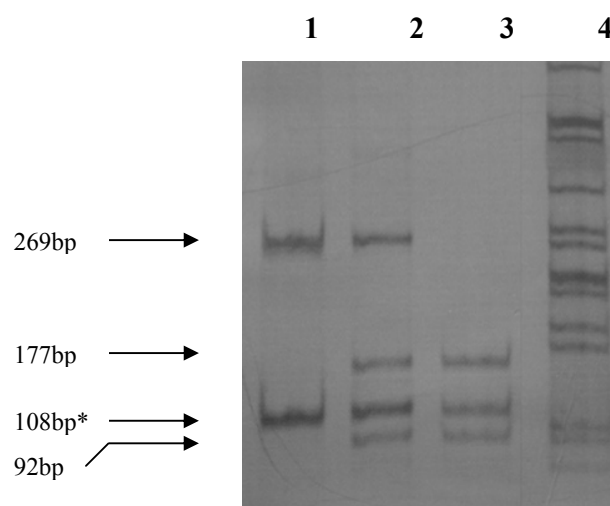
24. ASREA of the SNAP29 C56T polymorphism. Representative 12% polyacrylamide gel showing the fragment sizes generated by PCR and restriction digestion with DdeI. Lane 1: CC; Lane 2: CT; Lane 3: TT; Lane 4: Molecular weight marker λ Pst. The 108bp constitutive fragment is marked with an asterisk.
